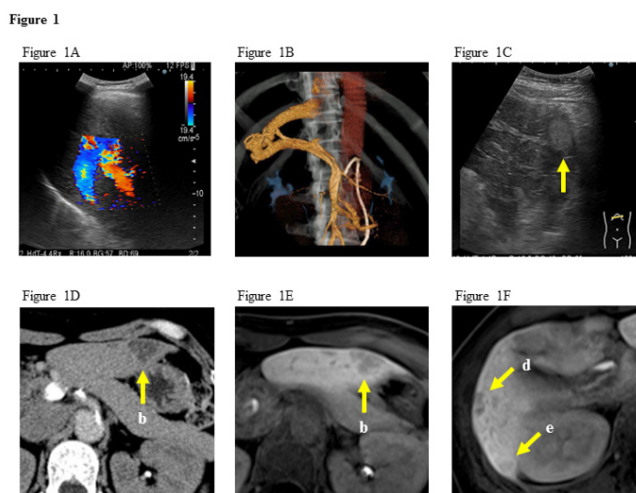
Findings of imaging studies. A. US imaging of the right lobe (Color Doppler Imaging). Shunt formation between right portal vein and right hepatic vein. B. Volume Rendering from CTAP. Shunt formation between right portal vein and right hepatic vein. C. US imaging in segment 3. Hyperechoic nodule. D. CTAP finding in segment 3. Perfusion defect. E. CEMRI in the hepatobiliary phase in segment 3 (‘b’). Hypointense nodule. F. CEMRI in the hepatobiliary phase in segment 5 (‘d’) and segment 6 (‘e’). Hypointense nodules.
